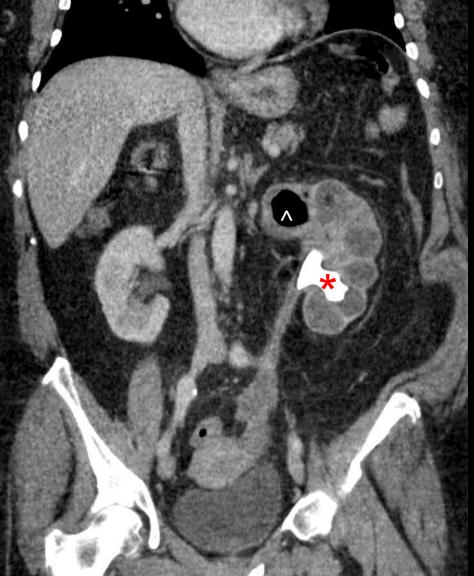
CT abdomen post contrast axial view.
